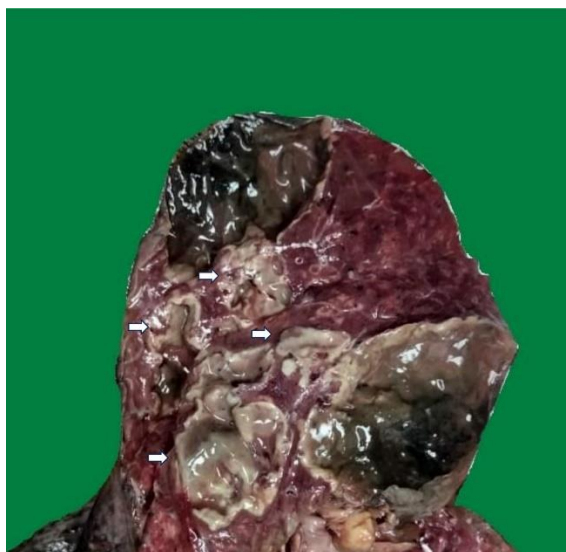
Showing a large, 5 cm diameter, cavitory lesion filled with blackish pigment and necrotic debris in apex of right upper lobe of lung also involving the pleural surface. Multiple smaller cavities are seen with tan brown necrotic material in the lumen (white arrows) which correspond to the ‘halo sign’ on CT scan.
